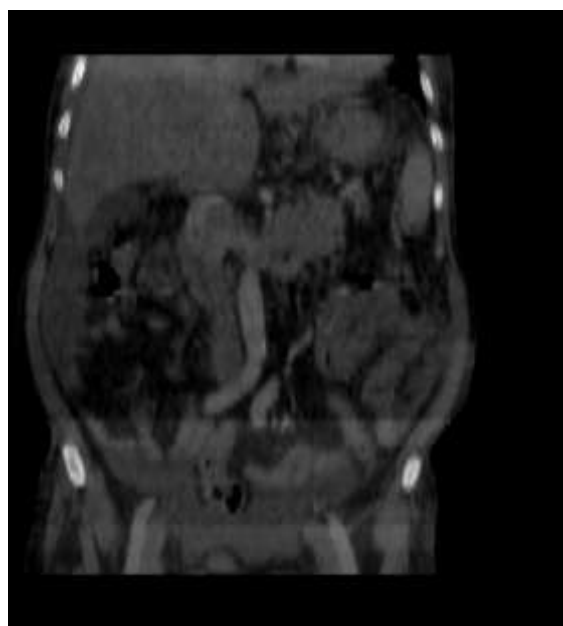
Coronal contrast-enhanced CT reconstruction demonstrating the left adrenal mass with contiguous extension of tumor thrombus into the left renal vein and inferior vena cava.
